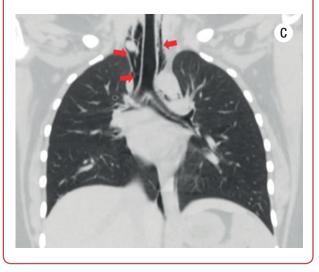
A: Chest computed tomography (CT) scan axial cut showing pneumomediastinum surrounding the oesophagus; B: Chest CT scan axial cut showing a defect in the anterior oesophagus concerning perforation; C: Chest CT scan coronal cut showing pneumomediastinum extending to the neck;
